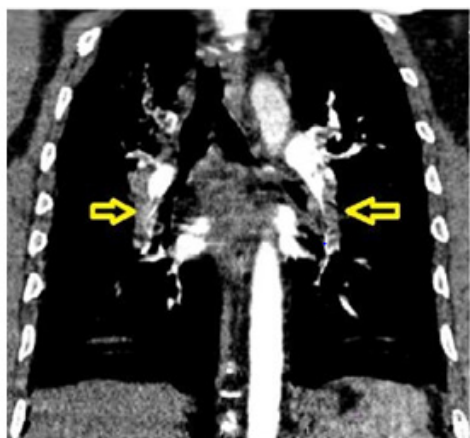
HRCT chest, coronal section showing thrombosis of bilateral pulmonary arteries (arrows).
